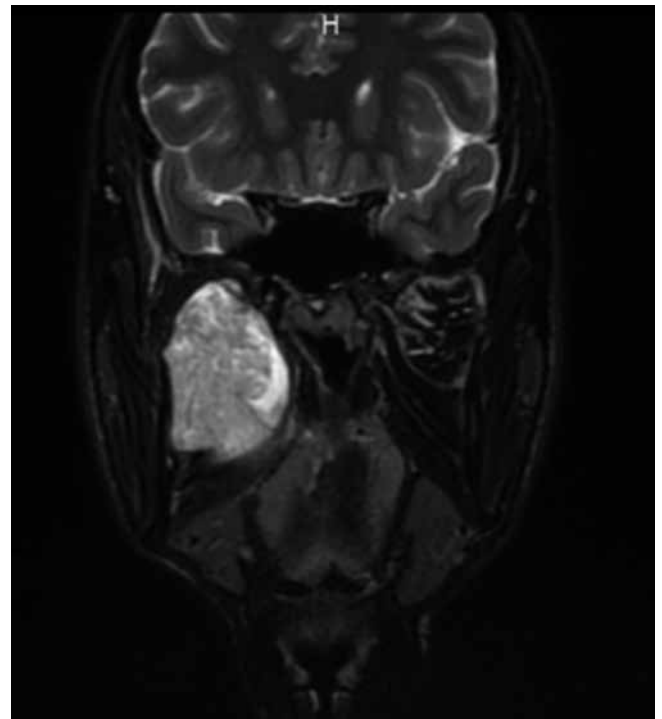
Axial T2-weighted MRI with contrast medium; presence of high signal intensity neoformation with sharp margins occupant the right parapharyngeal space (4 x 3 cm). Presence of central areas of colliquative necrosis and reduction of the hypopharyngeal space is visible
